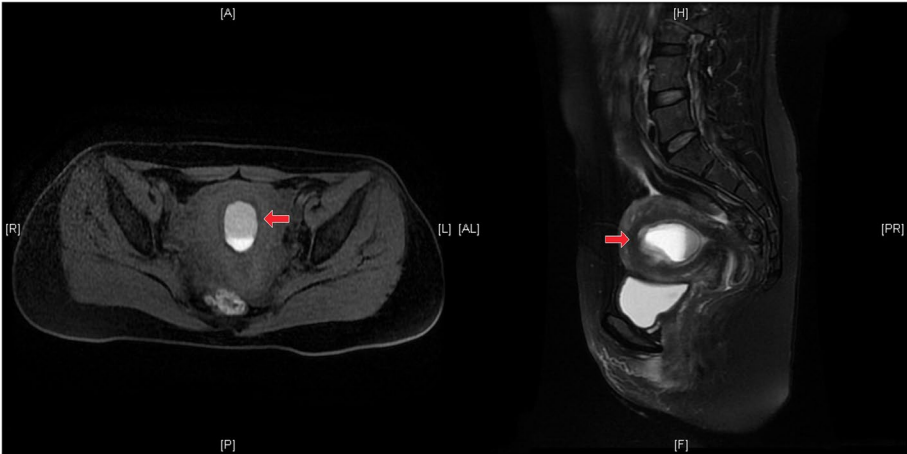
The MRI findings of Case1 reveal that the uterine mass exhibited characteristics of a cystic lesion, displaying hyperintensity on both T1-weighted and T2-weighted images. Liquid–liquid stratification can be observed in the capsule cavity
